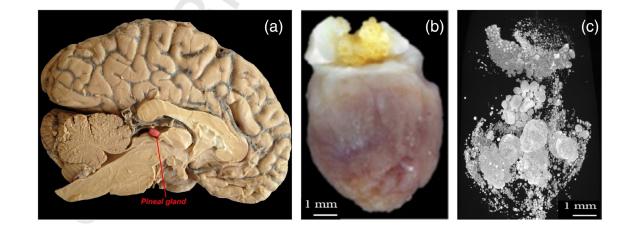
(a) Photographic image of the sagittal section of the human brain; (b) human pineal gland; (c) micro-computed tomography
